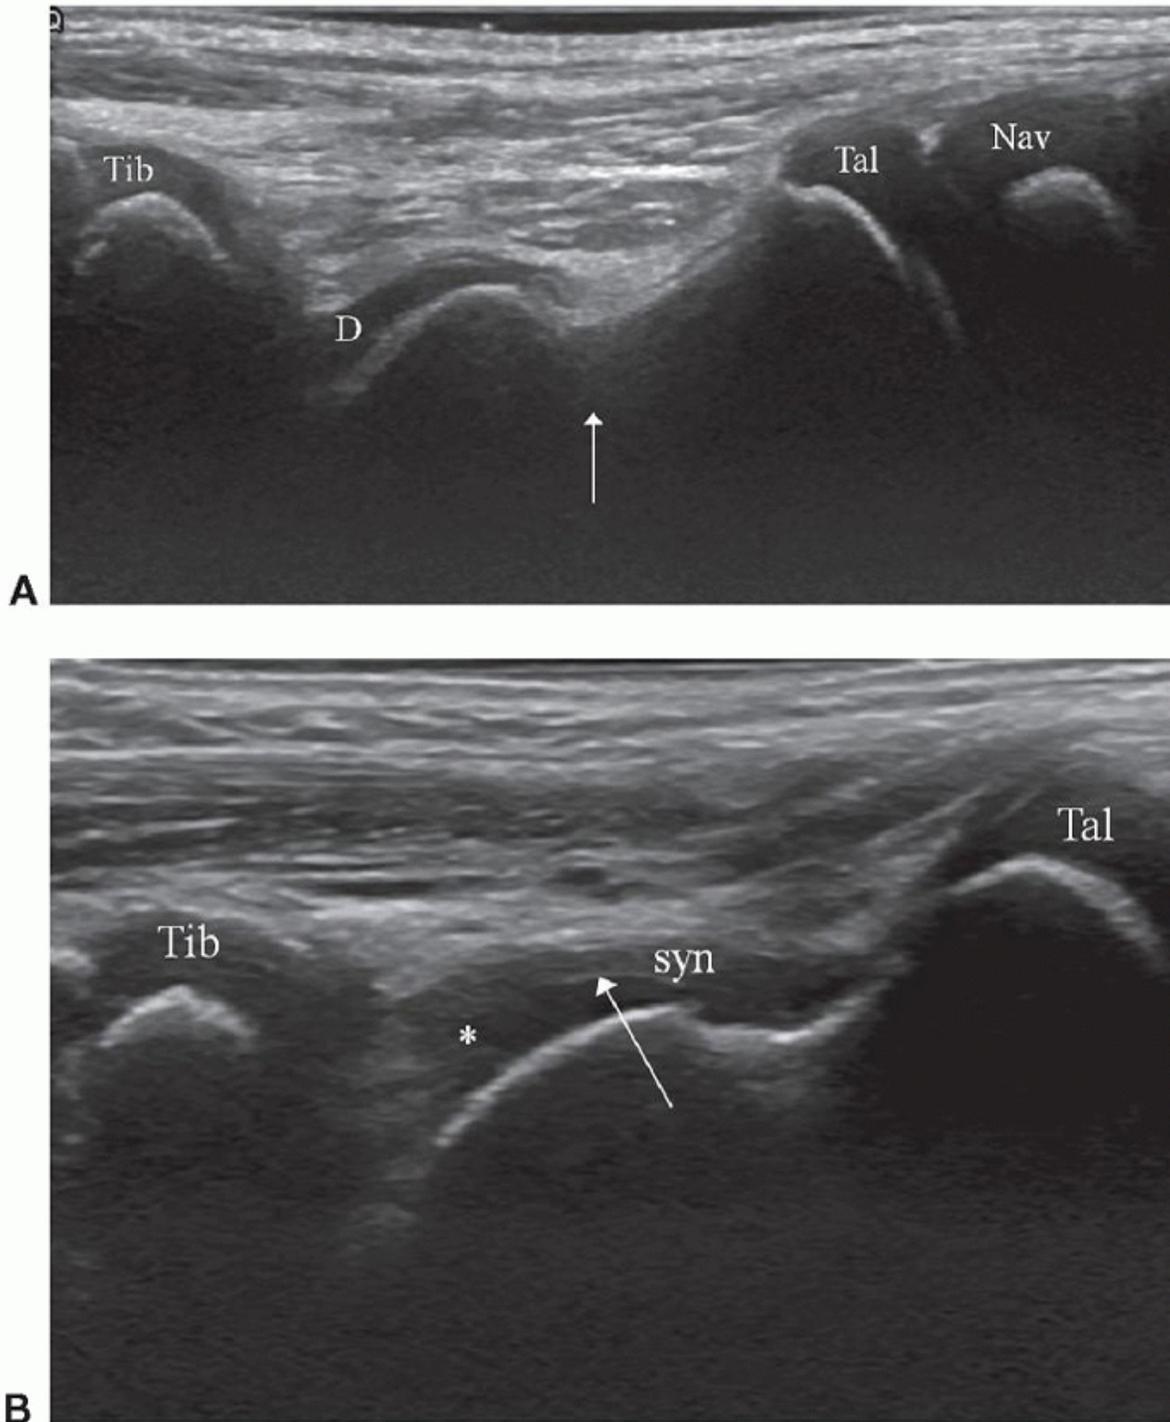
Dorsal longitudinal ultrasound scans of ankles of 4-year-old children. A: Normal ankle with thick hypoechoic cartilage on talar dome (D) and in growing epiphyses of distal tibia (Tib), distal talus (Tal), and navicular (Nav). No sign of synovitis. B: Juvenile idiopathic arthritis with hypoechoic synovial hypertrophy in anterior ankle joint recess. The interface between cartilage and synovium (syn) is seen when the ultrasound beam is perpendicular to the cartilage surface (arrow), but not identified when the ultrasound beam is angled due to anisotropy (asterisk).
